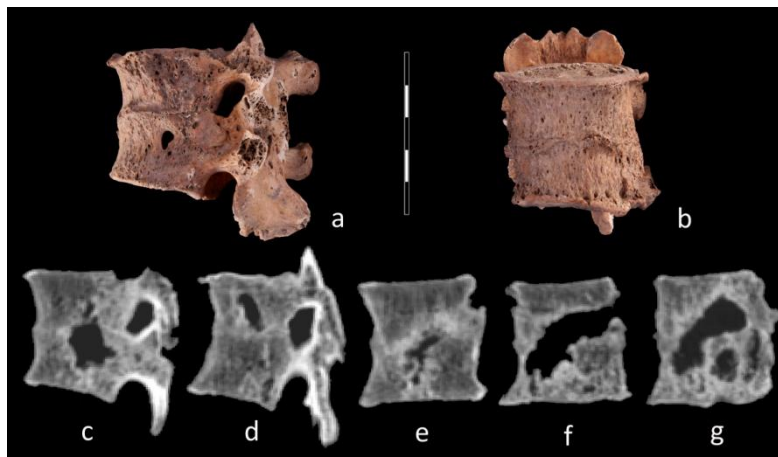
Complete fusion of the 10th and 11th thoracic vertebrae, both the macromorphological (a,b) and the CT-picture (c-g) reveal the presence of some non-specific infectious process.
